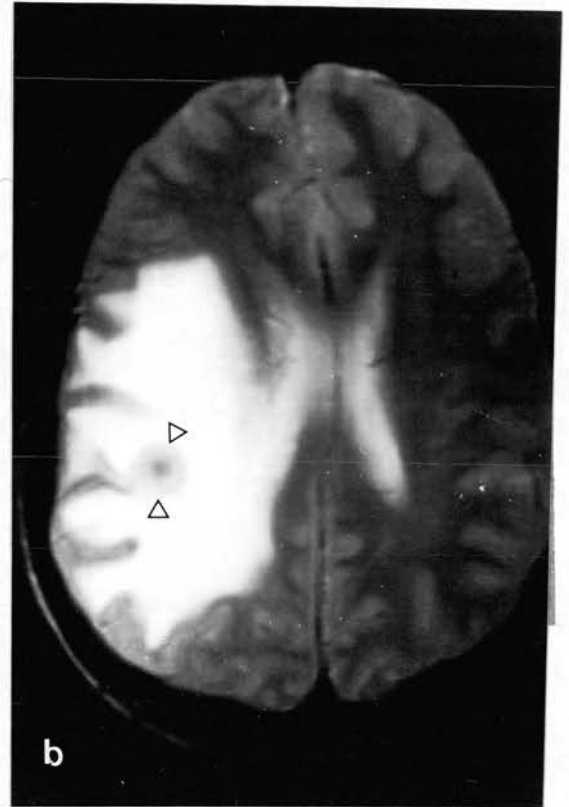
Neuroimaging of peritumoural oedema using CT scanning (A,C,D) and NMR (B). The spatial distribution of CT imaged oedema around a small postrolandic hemangioblastoma (arrows) (A) is very similar to that seen on a T₂ weighted NMR scan (B). Peritumoural oedema is generally maximal around glioblastomas (C) and metastases (D).
